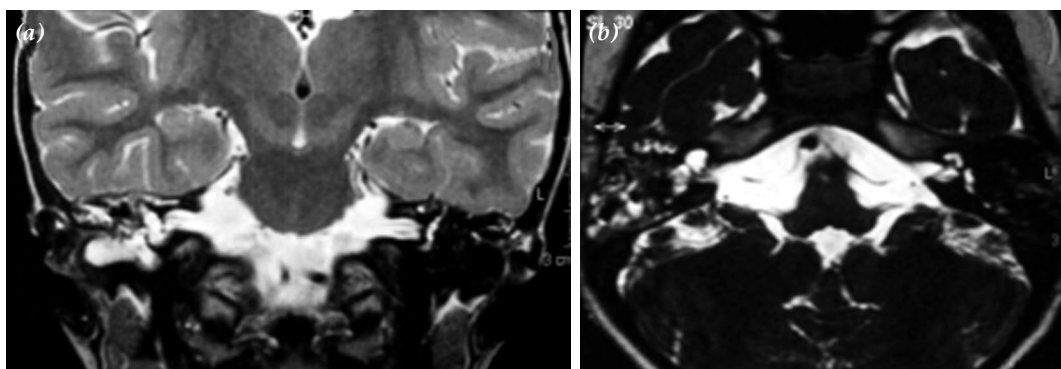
High signal within right sided mastoid cells and middle ear cavity, and a cystic dilatation with an incomplete configuration at right vestibule; (a) T₂-weighted coronal MRI, (b) T₂-weighted axial magnetic resonance imaging.
